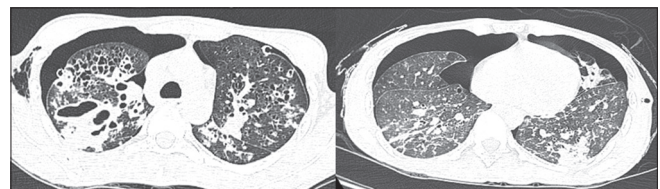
High-resolution computed tomography of the chest after 1-month of treatment showing increase in cavitation and new-onset consolidation and ground glass appearance bilaterally in the upper lobes; bilateral pneumothoraces and intercostal drains are also seen
